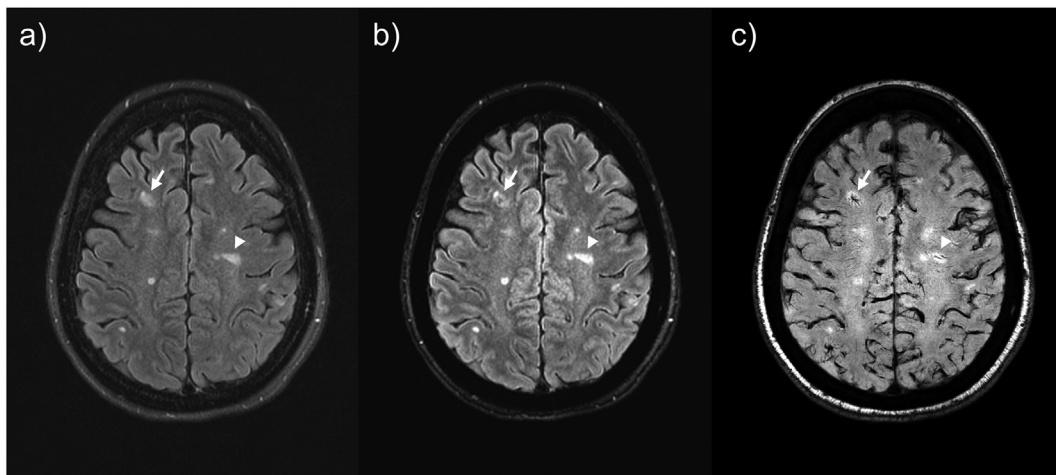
Representative tSWI-FLAIR in patient with MS. Multiple WMH lesions are shown on the T2 weighted FLAIR (a) data. By combining the tSWI derived from STAGE, the tSWI-FLAIR (b) had suppressed signal at the center of one WMH lesion (arrows). With the presence of an iron-based contrast agent (Ferumoxytol), the contrast enhanced tSWI-FLAIR (c) presented not only the central vein sign (arrow-head) but also a small venous angioma that clearly delineates the region of inflammation (arrow). The use of Ferumoxytol enhanced tSWI-FLAIR could help the study of WMH origins.
